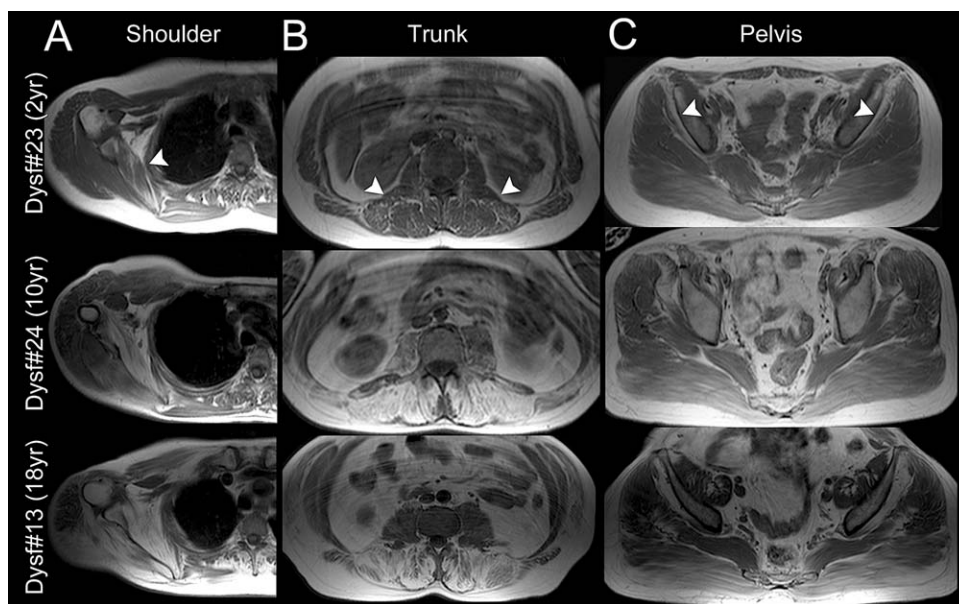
MRI of the shoulder (A), trunk (B), and pelvis (C). Axial T1W images of shoulder girdle, trunk, and pelvis of representative DDG1, 3, and 5 patients. The subscapularis, lumbar erector spinae, and gluteus minimus present with early involvement. Muscle involvement progresses to most remaining muscles according to disease duration. Arrowheads indicate the leading affected muscle in each segment. A, subscapularis, B, lumbar erector spinae; C, gluteus minimus.
